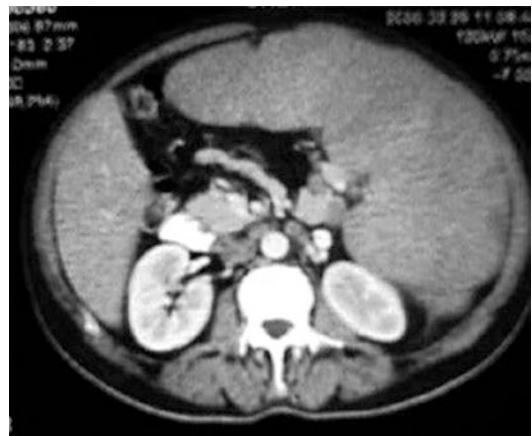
CT scan of a patient with CML requiring splenectomy
